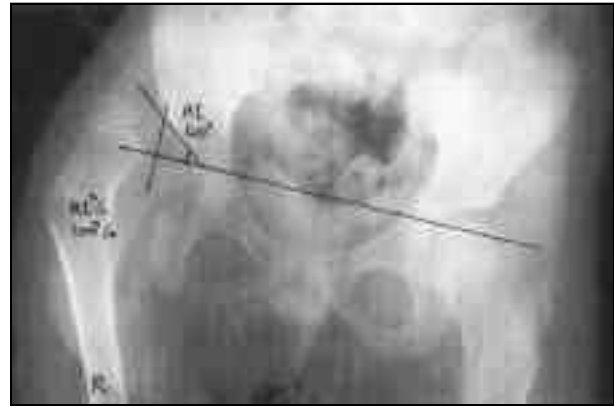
Case No. 14, Preoperative X-ray showing right hip dislocation
